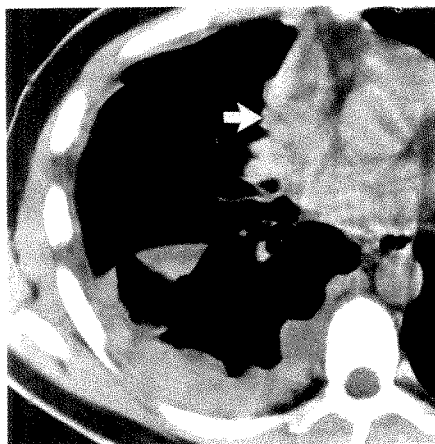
1-cm collimation CT scan at level of left atrium in a patient with metastatic melanoma shows right-sided nodular pleural thickening  $>1$  cm. Nodular thickening also involves mediastinal pleura (arrow) and major fissure.
